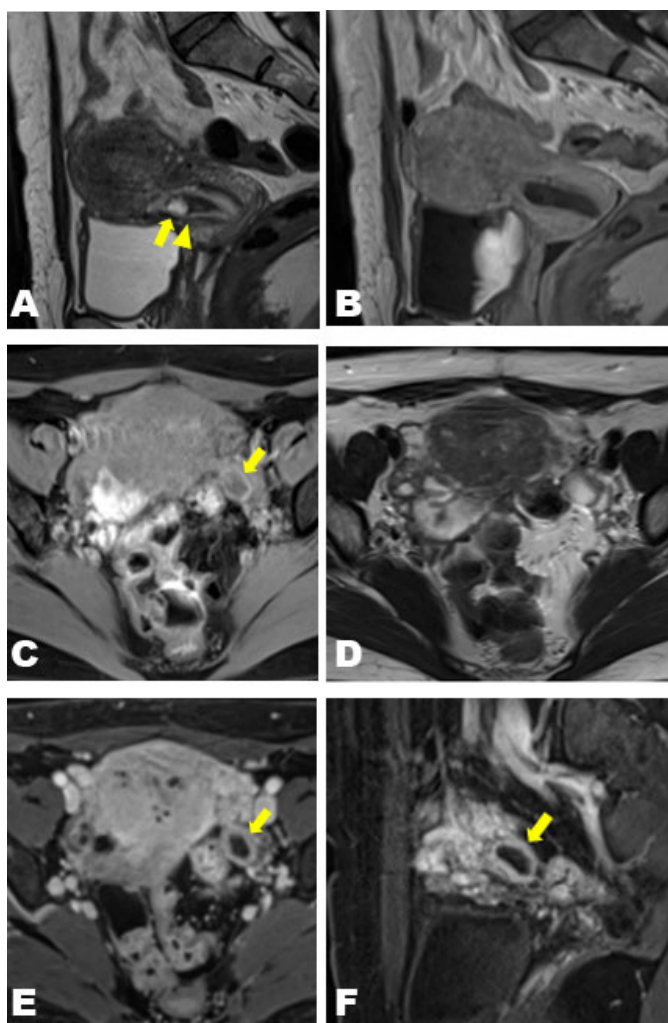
Magnetic resonance imaging of the pelvis. (A) Sagittal T2-weighted image showing a cystic structure (arrow) on the anterior wall of the lower uterine segment in the region of the previous cesarean section scar. The adjacent linear low-signal area suggests a clot (arrowhead). The uterine cavity was empty. (B) The intrauterine cystic lesion lacks contrast enhancement after Gd-DTPA administration on a dynamic T1-weighted image (arrow). (C) Axial fat-suppressed T1-weighted image shows another cystic left adnexal lesion with a highly intense thick wall (arrow) close to the left ovary. (D) The mass is close to the left ovary on axial T2-weighted images. (E, F) Ring-like enhancement of the lesion is found on both axial (E) and sagittal (F) fat-suppressed dynamic T1-weighted images (arrow).
